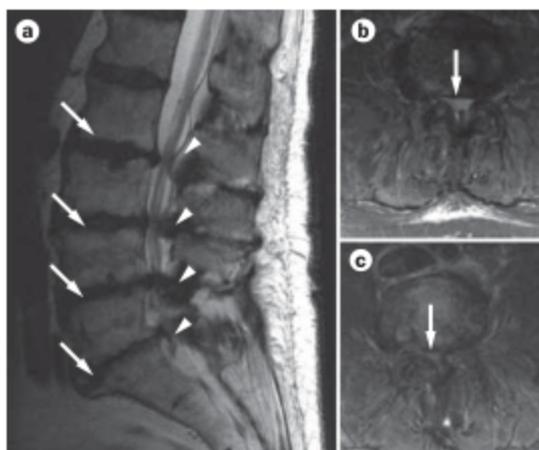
Spinal alterations in a patient with multisegmental LSS. Sagittal and axial images were obtained using T2-weighted turbo spin-echo MRI. a | A sagittal image reveals multisegmental LSS with signs of spondylosteoarthrosis, such as disc height and signal reduction, disc herniation, irregularity of end plates and bone marrow degeneration (arrows), and spondylarthrosis (hypertrophy and sclerosis of the facet joints; arrowheads). The axial images depict b | a moderate (arrow) and c | a severe (arrow) central LSS with different degrees of disc pathology, hypertrophy of ligamenta flava and facet joints. Abbreviation: LSS, lumbar spinal stenosis.
